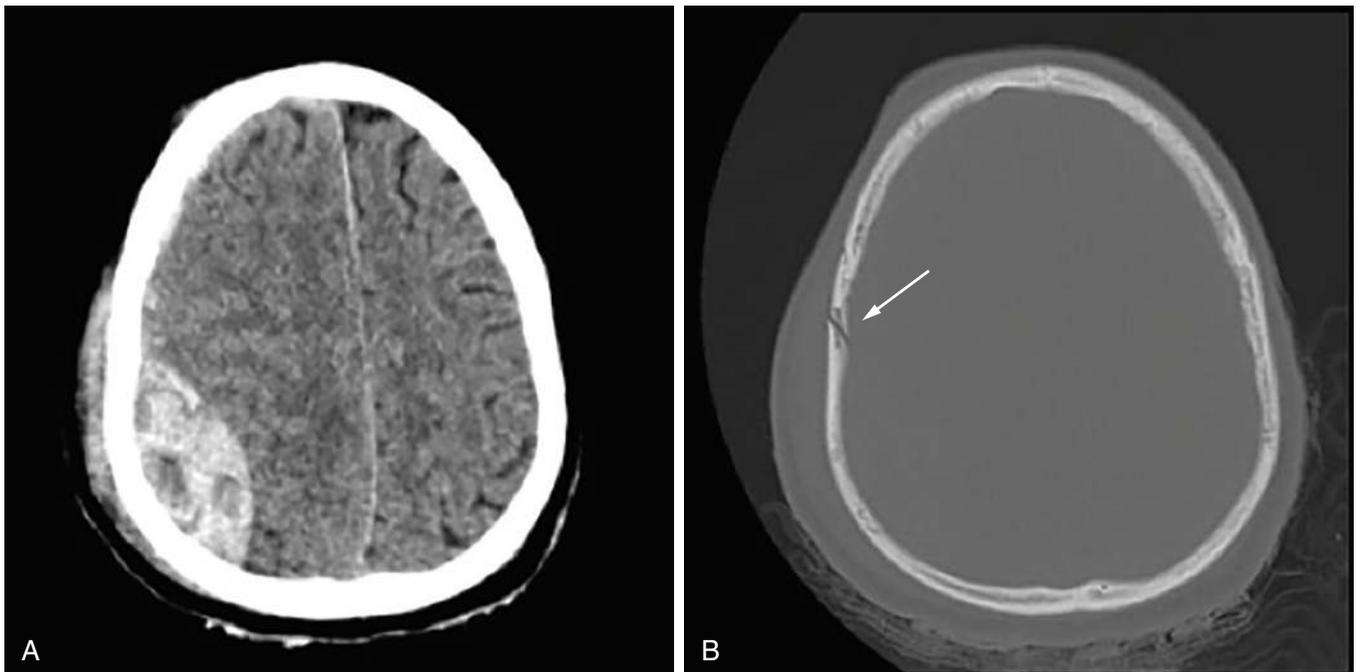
Epidural hematoma. A, Noncontrast CT shows a hyperdense, lens-shaped extraaxial collection representing an acute epidural hematoma in this patient with closed head injury. B, Same CT viewed in bone windows shows a nondisplaced calvarial fracture (*white arrow*) associated with the epidural hematoma.
